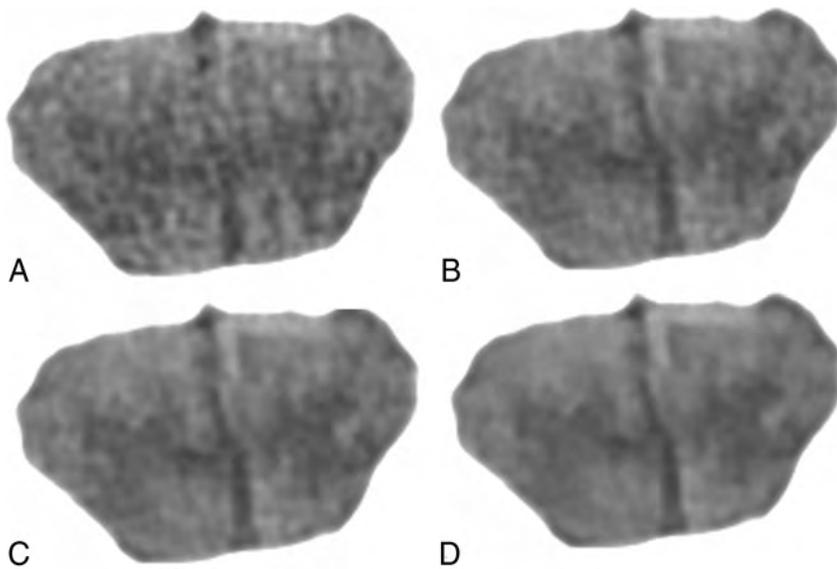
Benchmark coronal head CT images for rating scales of image texture: 409 mAs with FBP for score = 4 (A), 982 mAs with FBP for score = 3 (B), 982 mAs with ADMIRE-3 for score = 2 (C), and 982 with ADMIRE-5 for score = 1 (D).
